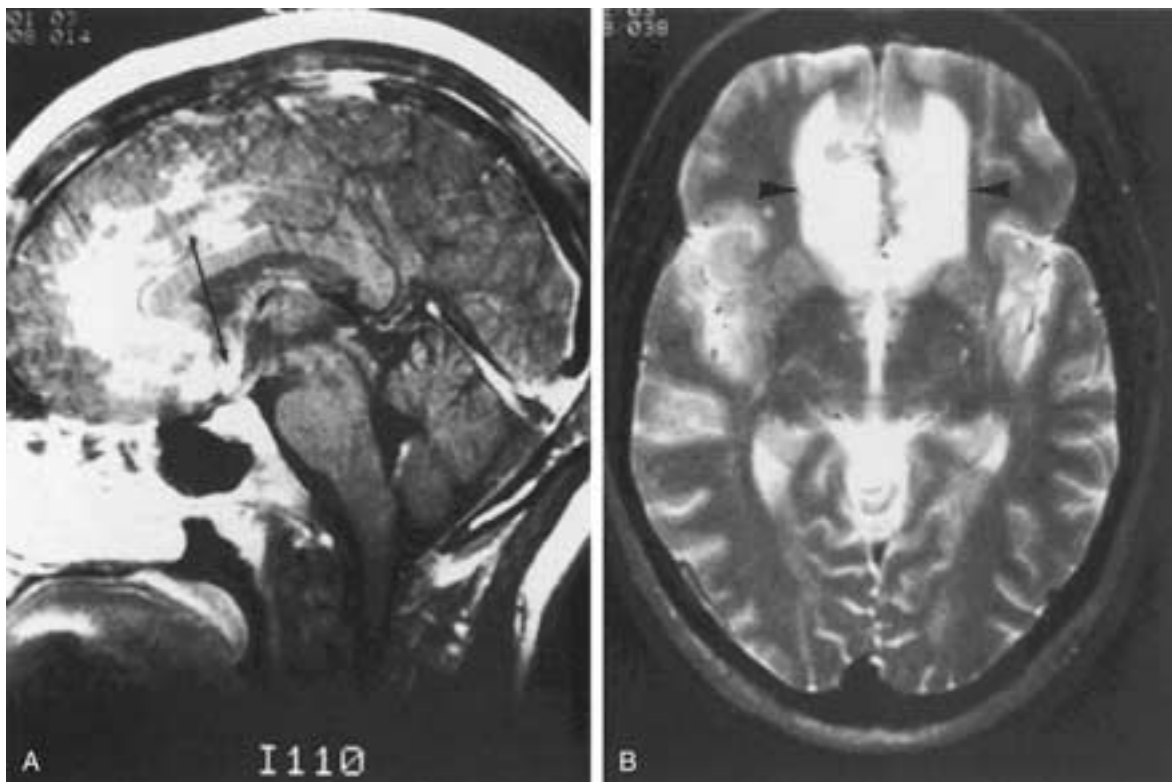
Leptomenigeal sarcoidosis. A, Sagittal T1-weighted image after injection of contrast material shows marked enhancement of leptomeninges between the frontal lobes, extending along the corpus callosum, and down onto the surface of the optic chiasm (*arrow*). B, Axial T2-weighted image shows bifrontal edema (*arrowheads*) within the cortex and white matter of the frontal lobes at the site of leptomenigeal involvement by sarcoid.
